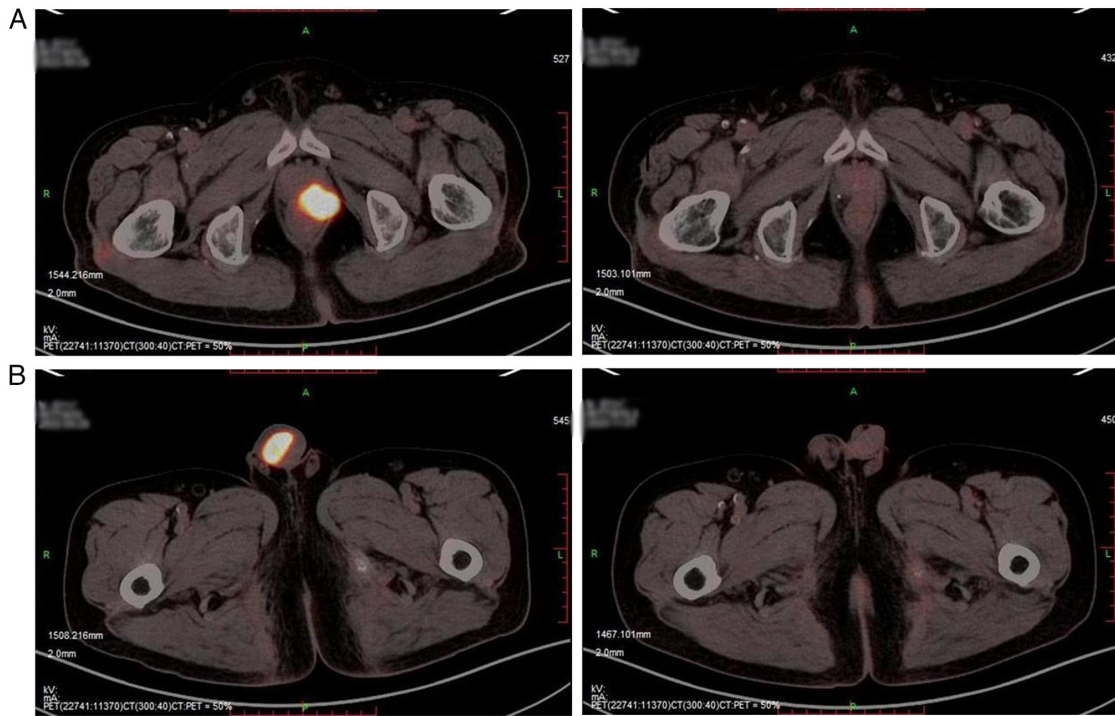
Prostate-specific membrane antigen PET/CT images of the (A) prostate and (B) penis before and after treatment. The PET/CT images on the left were taken before treatment and those on the right were taken after treatment. PET/CT, positron emission tomography/computed tomography.
